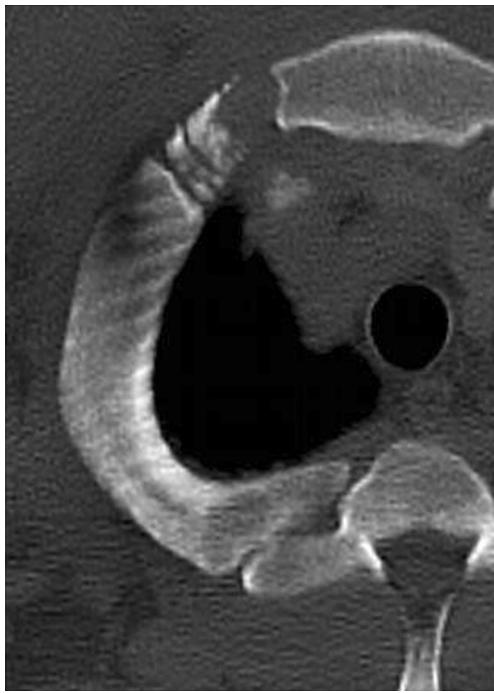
The CT image of the third cartilage stage (SIEMENS Syngo MultiModality Leonardo Workplace, bone window, multi planar reconstruction—MPR, oblique plane adjusted to the plane of the first cartilage)
